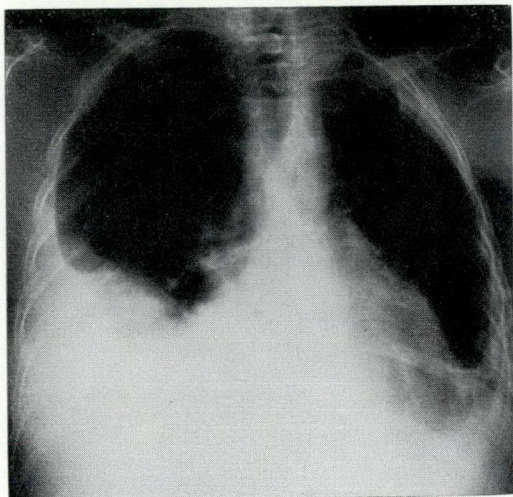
Posteroanterior chest radiograph, September 23, 1963. A massive pleural effusion has recurred on the right side, and somewhat obscures the cardiac outline.
